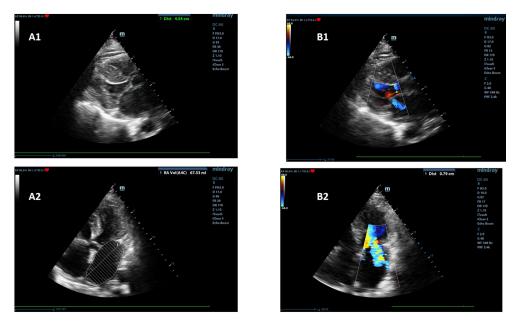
b.9. Left: dilated left atrium with antero-posterior diameter of 4.54 cm (A1: 2D-parasternal long axis view), LAVi=37 ml/m<sup>2</sup> (B2: 2 D, 4-chambers view modified for LA). Right: moderate mitral regurgitation (B1: color Doppler, parasternal long axis view, B2: color Doppler, 4 chambers view)
